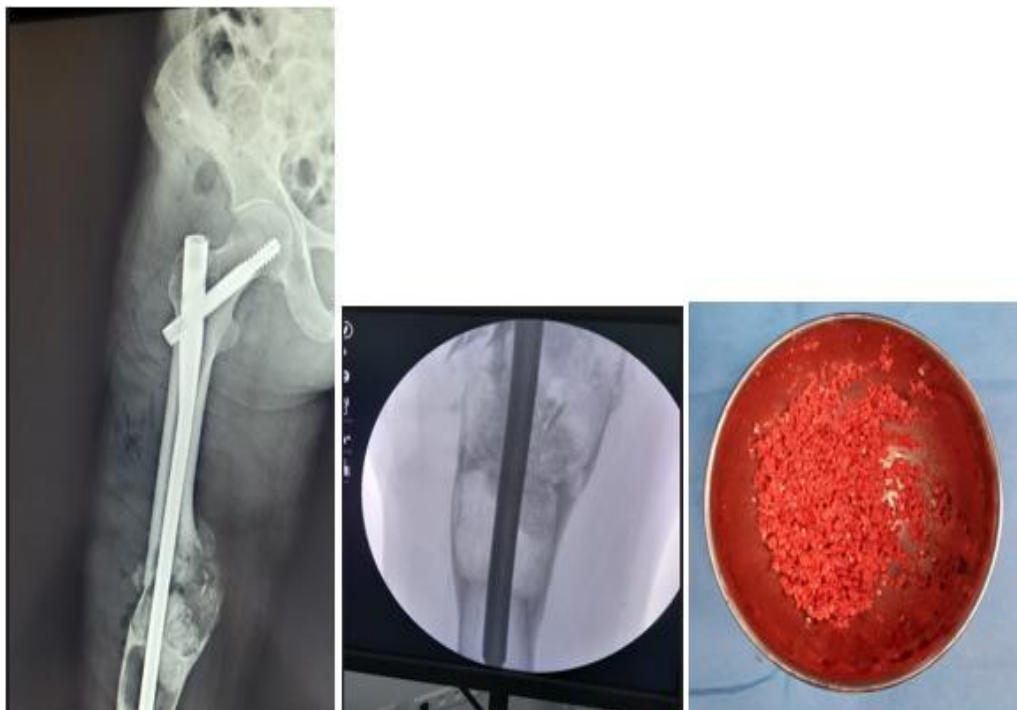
Intraoperative curettage, bone cavity filled with a mixture of autologous bone graft and bone substitute, internal fixation with a long gamma nail, and postoperative radiograph showing proper alignment
